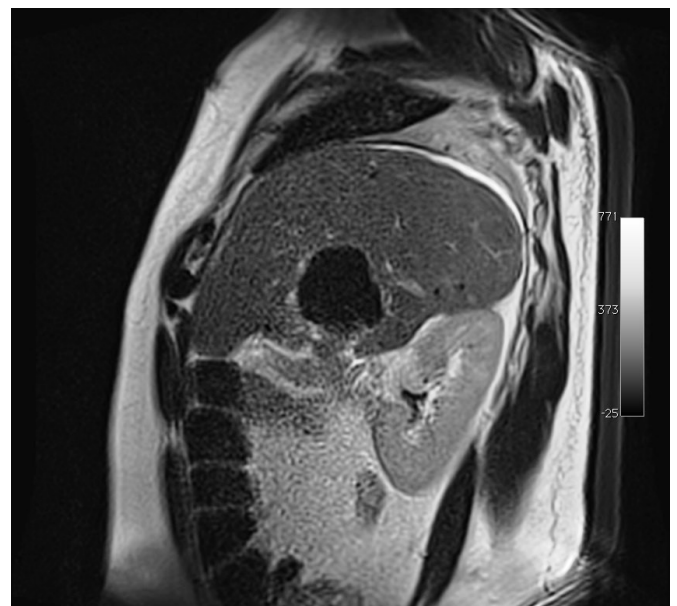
Liver MRI – T2 sagittal plane. Cryotherapy (ice ball-hypointense)
